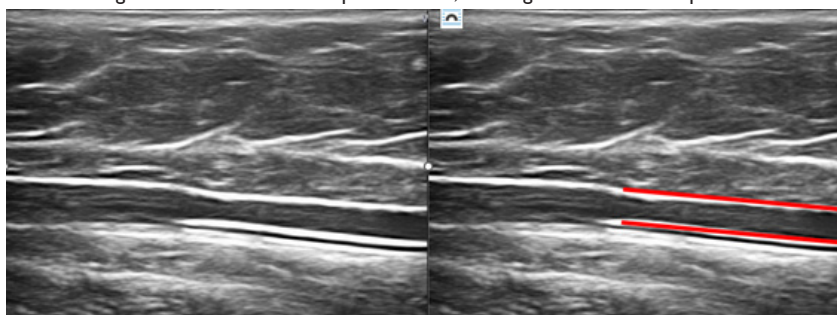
Ultrasound image in longitudinal section showing position of the endoluminal Arrow catheter.
